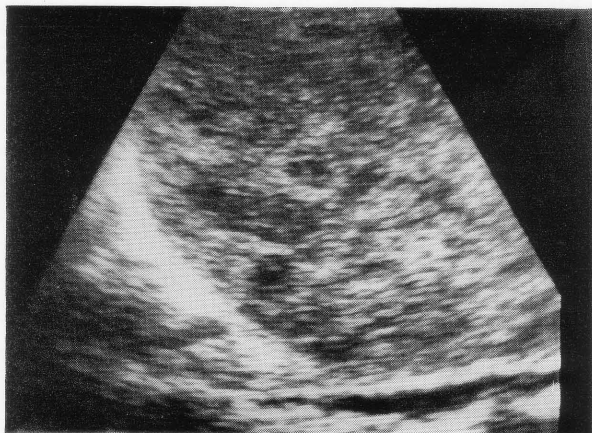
Longitudinal sonogram of the upper abdomen. Degenerative changes in a part of a large subserous leiomyoma mimicking the sonographic findings of molar gestation.
